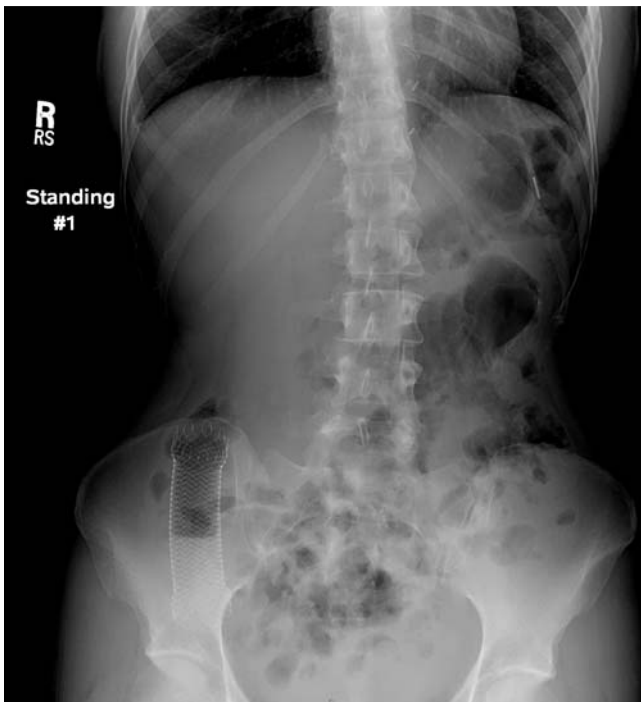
Upright abdominal plain film showing stent in right lower quadrant; no dilated loops of bowel or free intraperitoneal air is seen.
